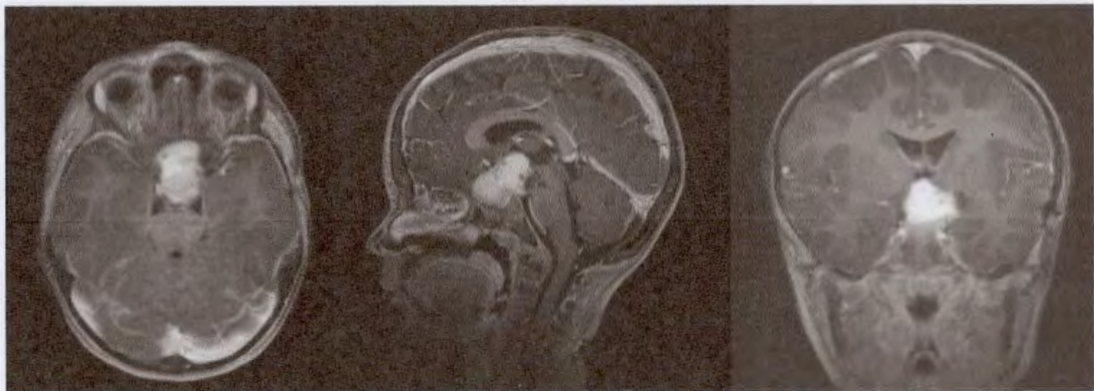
T1-weighted MRI with contrast. Axial, sagittal and coronal view of a 4-year-old boy with a sporadic OPG infiltrating the chiasm.
